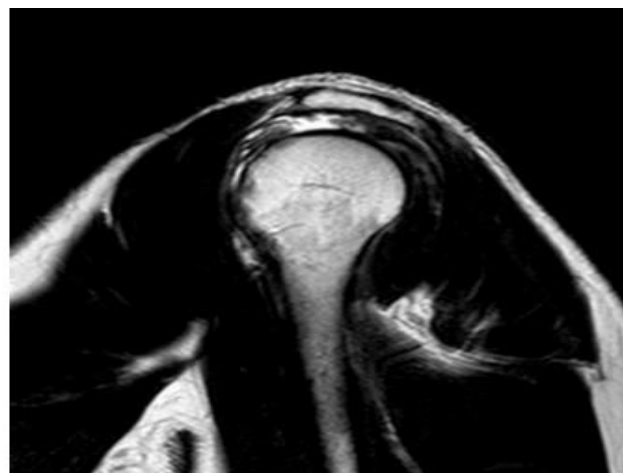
MRI, T2WI, sagittal view showing full thickness tear of supraspinatus.⁴
